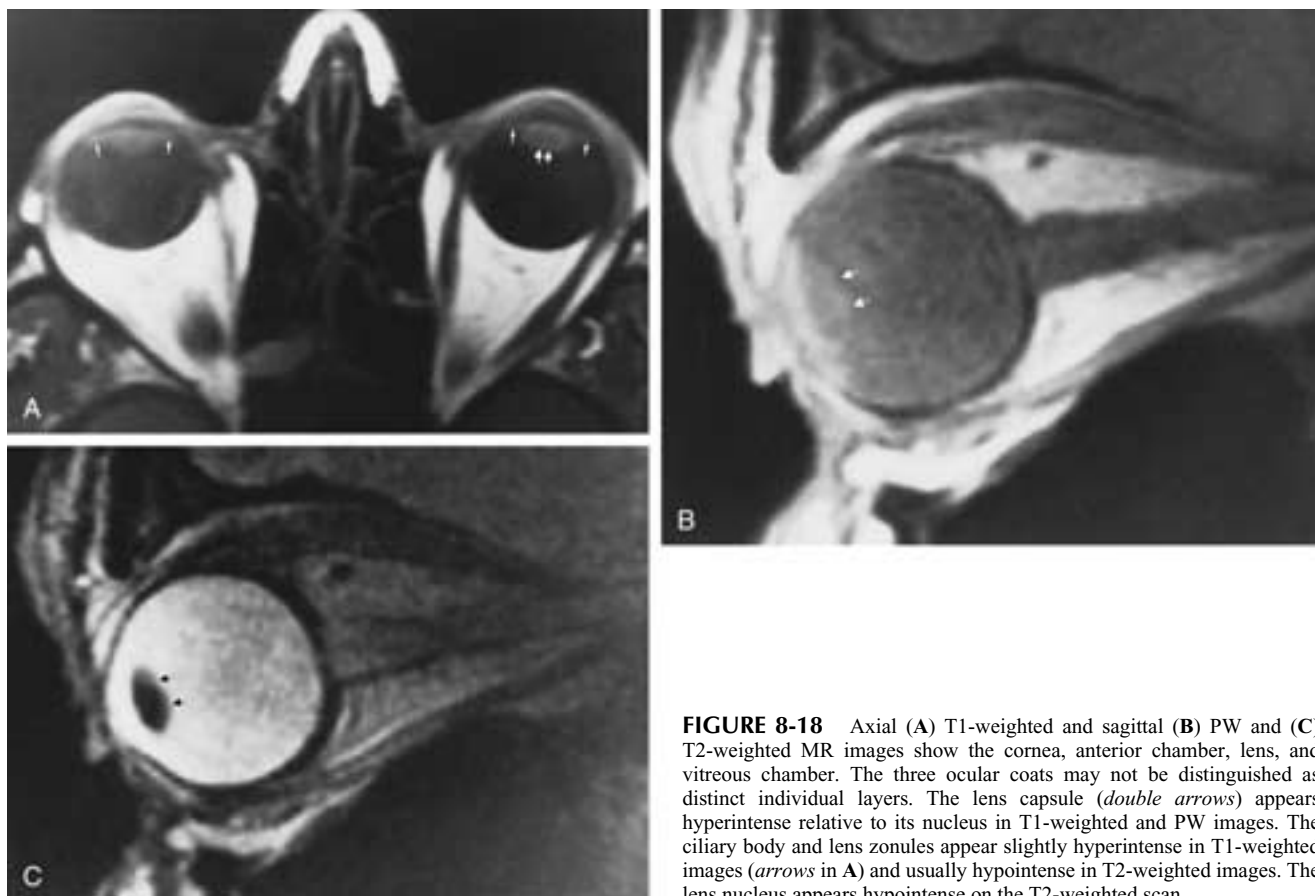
Axial (A) T1-weighted and sagittal (B) PW and (C) T2-weighted MR images show the cornea, anterior chamber, lens, and vitreous chamber. The three ocular coats may not be distinguished as distinct individual layers. The lens capsule (*double arrows*) appears hyperintense relative to its nucleus in T1-weighted and PW images. The ciliary body and lens zonules appear slightly hyperintense in T1-weighted images (*arrows* in A) and usually hypointense in T2-weighted images. The lens nucleus appears hypointense on the T2-weighted scan.
